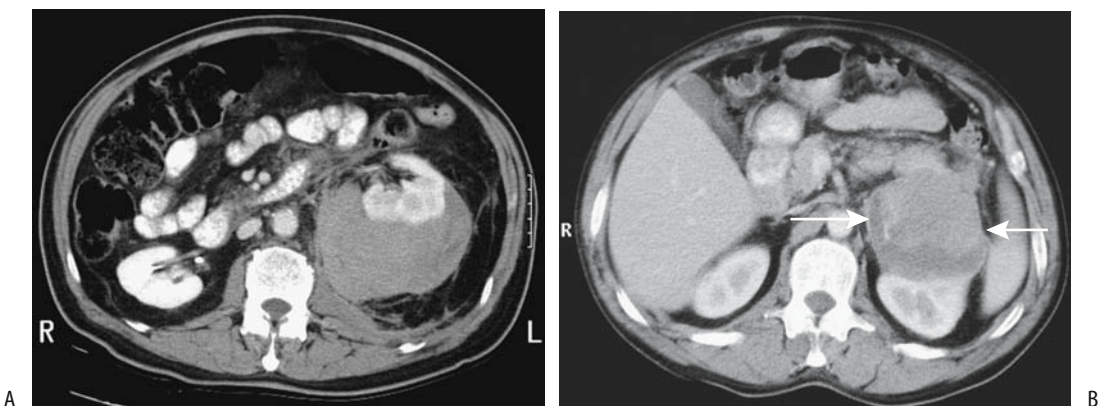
Perirenal hematoma. A: CT identifies left perirenal fluid in a man who fell down stairs. (Courtesy of Patrick Fultz, M.D., University of Rochester.) B: Contrast-enhanced CT in another patient reveals a focal fluid collection anterior to the left kidney (arrows). (Courtesy of Algidas Basevicius, M.D., Kaunas Medical University, Kaunas, Lithuania.)
